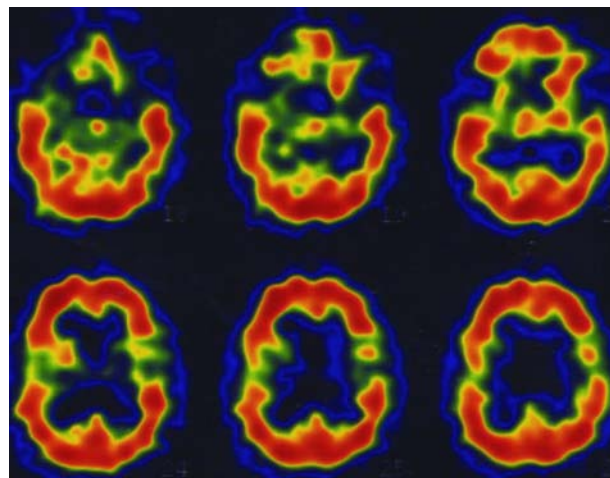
A 99mTc-hexamethyl propylene amine oxime single photon emission computed tomography of the proband at the age of 73 years showing bilateral sylvian hypoperfusion.
